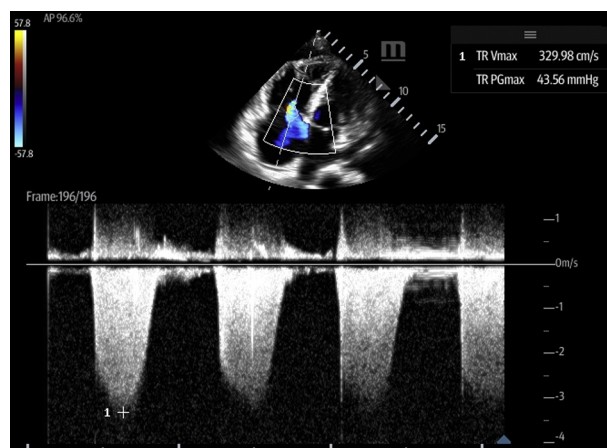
Moderate-to-severe tricuspid regurgitation in the apical four-chamber view using continuous-wave Doppler. The signal is dense, eccentric toward the septal wall, between parabolic and triangular, and has an early peak velocity. There also appears to be a wide vena contracta. To even further improve this assessment, the color box should be focused only over the tricuspid valve and its retrograde chamber (right atrium).
